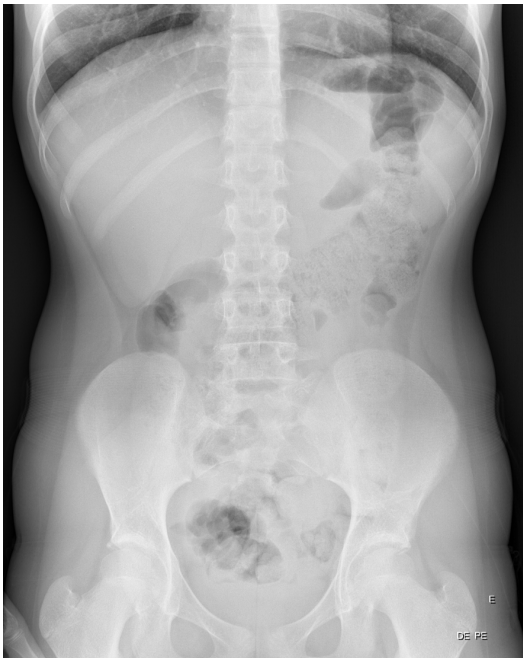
Abdominal radiograph, standing, without significant changes, namely signs of pneumoperitoneum.
